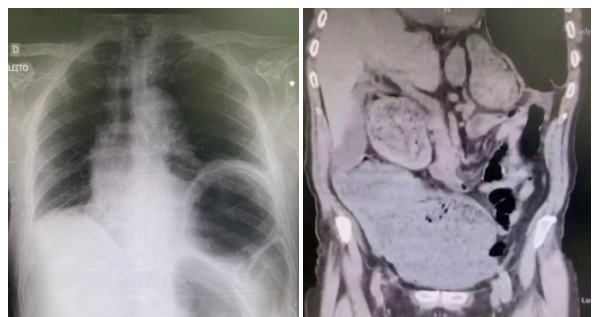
Chest X-ray / Image 2: Contrast-enhanced CT scan of the abdomen
